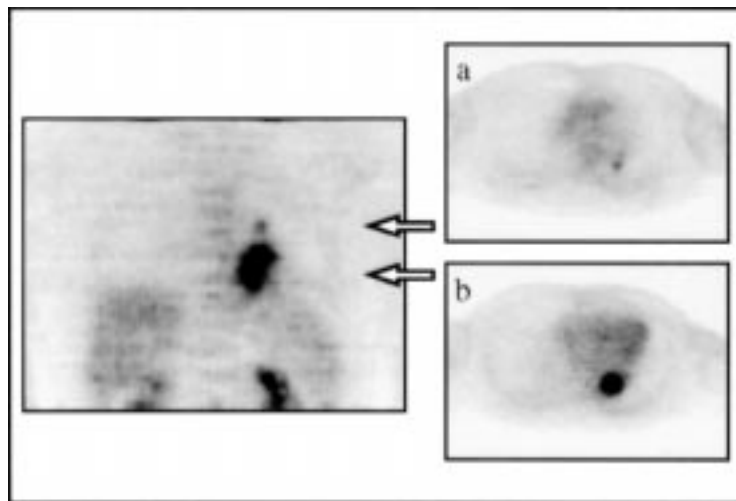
Coronal (left) and corresponding transaxial (right) FDG-PET scans of a patient with squamous cell carcinoma (pT3 pN1) of the left lower lobe. An ipsilateral peribronchial lymph node metastasis (a) as well as the primary tumour (b) are clearly visualised by focal FDG uptake.
